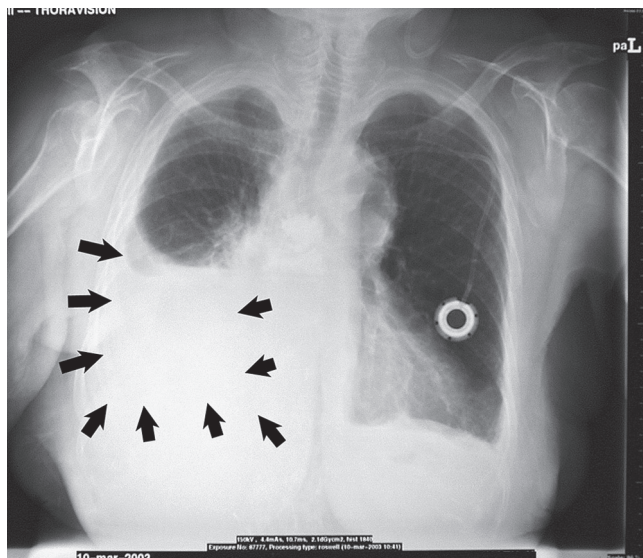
■ Chest roentgenogram showing large right pleural effusion (outlined by arrows).
